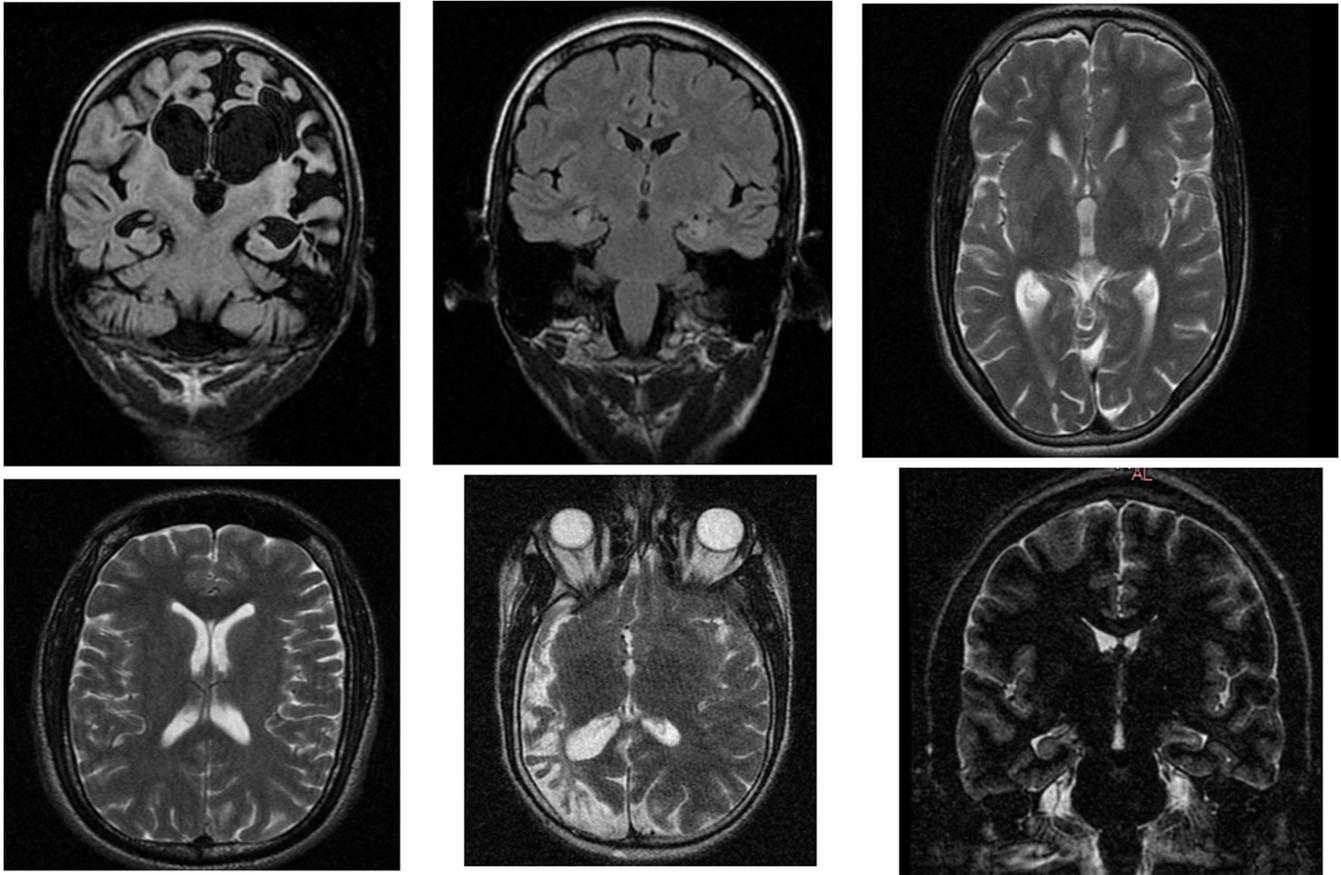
Types of magnetic resonance imaging (MRI) abnormalities. First row, left to right: hypoxic-ischemic encephalopathy (HIE) at term and bilateral mesial temporal sclerosis (MTS) in an 8-year-old girl; mild generalized cerebral atrophy in a 17-year-old boy and bilateral MTS in a 29-year-old woman. Second row, left to right: Normal scan in a 25-year-old man and encephalomalacia in an 18-year-old woman, and left MTS coronal T2 in an 18-year-old man.
